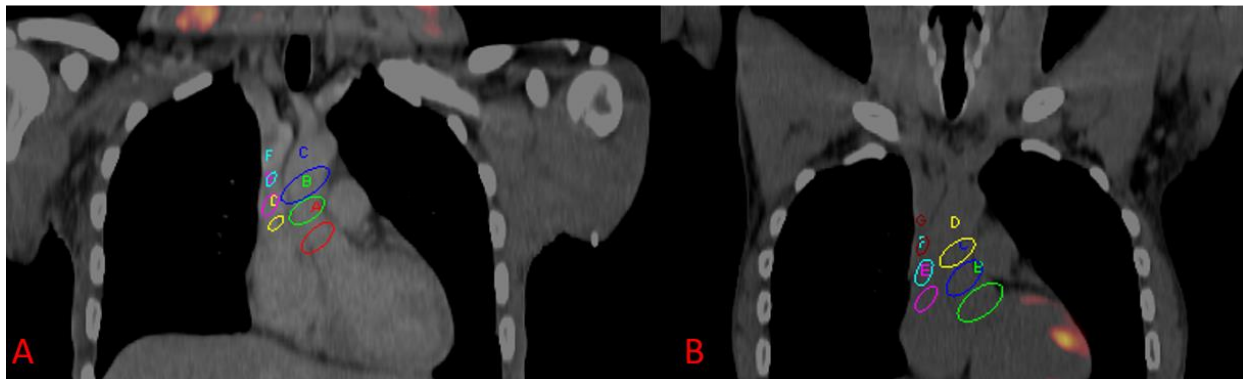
Fused ^{18}F -FDG PET/CT images through the chest of a 40-year-old male who had baseline (A) and follow-up imaging post-chemotherapy (B) for Hodgkin lymphoma. This figure depicts how SUVmax and TBR were calculated for each arterial bed using the ascending aorta and the superior vena cava for demonstration. Multiple regions of interests (ROI) are shown encircling the ascending aorta. The mean SUVmax obtained from these ROIs represents the aortic SUVmax. Multiple ROIs are shown within the lumen of the superior vena cava (SVC). The mean of the SUVmean from these ROIs represent the SVC SUVmean. TBR for the ascending aorta was computed by dividing
